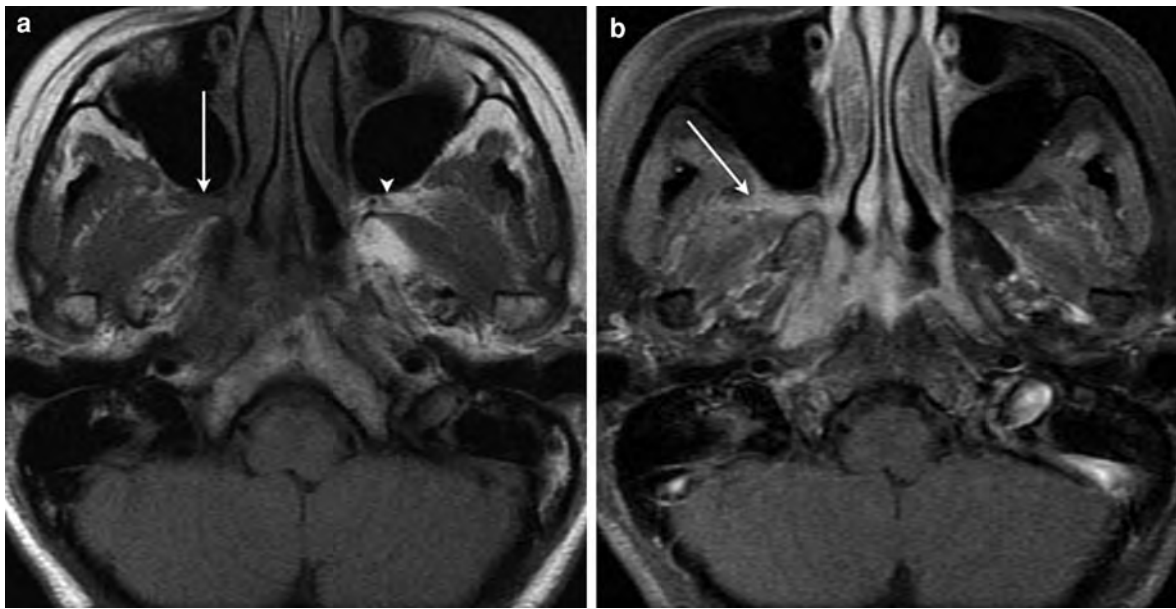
a Axial T1-weighted MR image shows a nasopharyngeal carcinoma spreading through the right sphenopalatine foramen into the right pterygopalatine fossa (*arrow*). Note the normal hyperintense fat in the contralateral pterygopalatine
